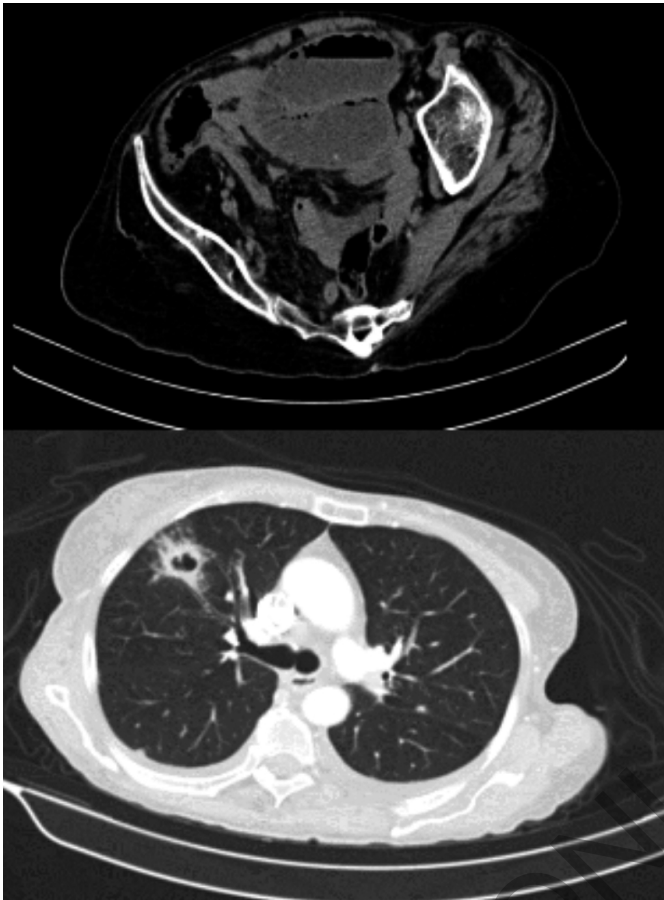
Abdominal + Chest CT scan: dilated bowel loops to the jejunum and excavated consolidation areas.
